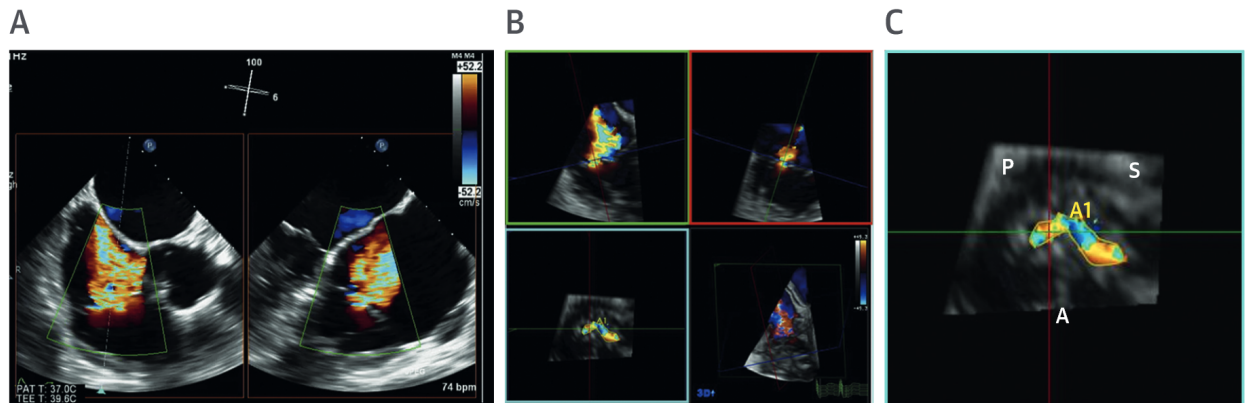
Because the shape of the TR jet is frequently irregular, the vena contracta (VC) diameters vary based on the imaging window. (A) Simultaneous multiplane imaging shows different VC diameters. The 3D color Doppler image (B) aligns the green and red planes to image the VC in the blue plane. (C) The blue plane with S, P, and A leaflets with the regurgitant jet between both the A-S and A-P commissures. A = anterior leaflets; P = posterior leaflets; S = septal leaflets;
